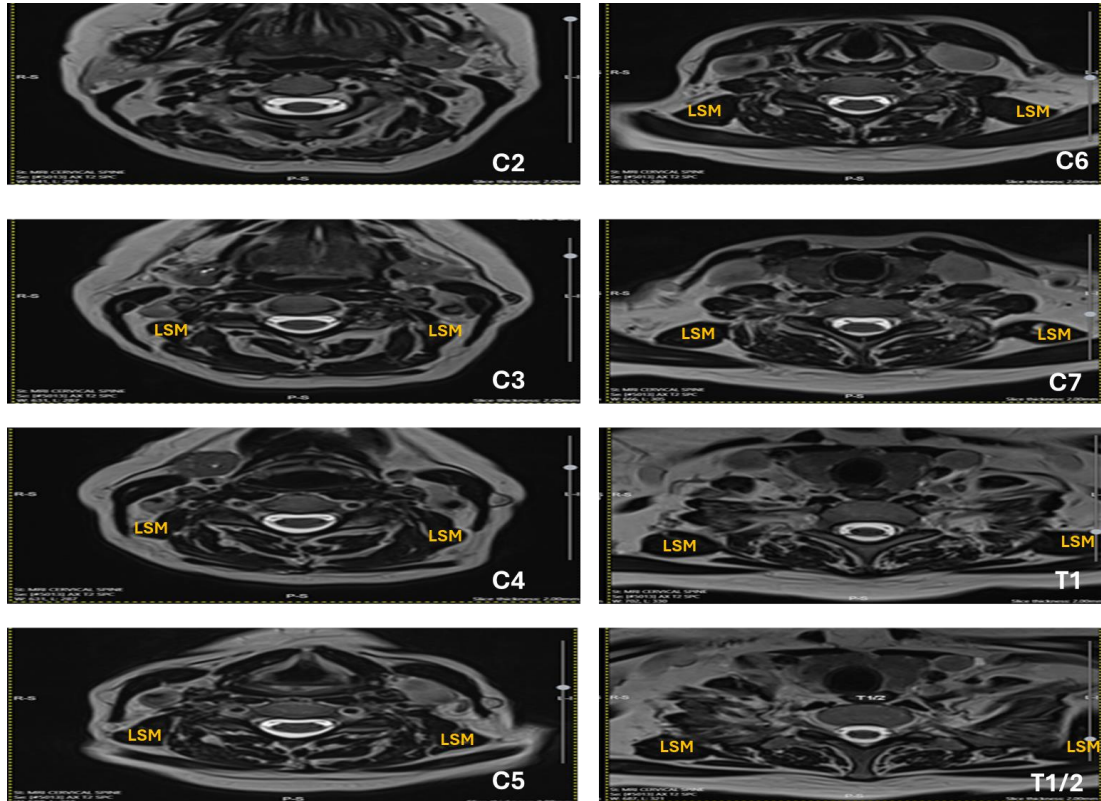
The axial cervical MRI scans with identified levator scapulae muscle (LSM). Key: C1-C7: cervical vertebral 1-7, T1: thoracic vertebral 1, T1/2: between thoracic vertebral 1 and 2.
